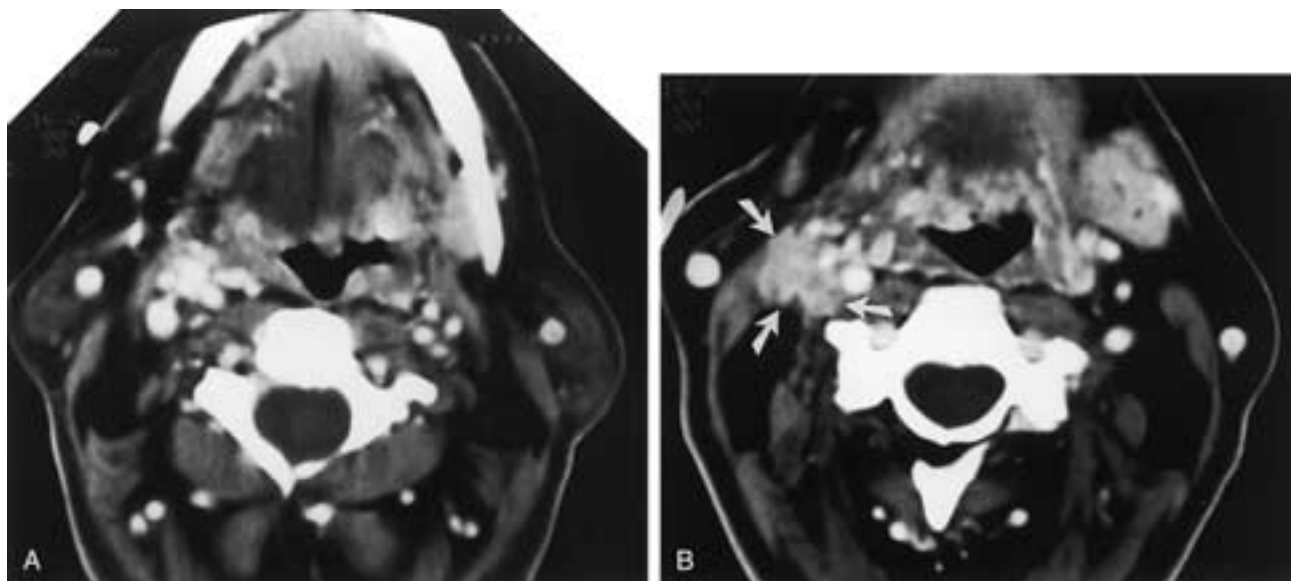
Early chronic hypoglossal nerve denervation. A and B, Axial CT scans in a 46-year-old woman 8 years after mastectomy for breast carcinoma who now presents with right cranial nerve XII palsy. At the level of the mandible (A), fatty replacement and loss of muscle fibers involving the intrinsic musculature and genioglossus muscles of the right hemitongue are identified by its lower density compared with the left hemitongue. On a more inferior plane (B) an extranodal mass is visible adjacent to the right carotid sheath (arrows), which proved to be metastatic breast carcinoma. This case highlights the importance of imaging the most inferior loop of the hypoglossal nerve, inferior to the mandible, so as to visualize nerve XII fibers coursing in the low oropharyngeal carotid space.
